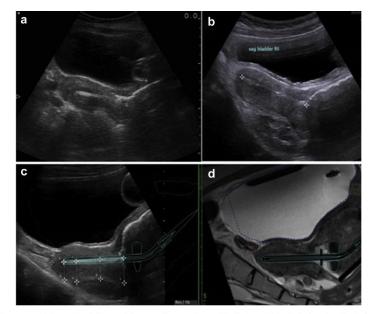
Example of improvements in quality of ultrasound images with new ultrasound technology. (a) Sagittal view of applicator in uterus taken in 2008 with Falcon ultrasound unit (BK-Medical, Herlev, Denmark). (b) Sagittal view of applicator in uterus taken in 2010 with Flex focus 400 ultrasound unit (BK-Medical, Herlev, Denmark). (c) Sagittal view of applicator in uterus taken in 2012 with Flex focus 400 ultrasound unit (BK-Medical, Herlev, Denmark). (d) Sagittal view of applicator in uterus on MRI taken in 2012 same patient as image c. Source of all images: Peter MacCallum Cancer Center.
